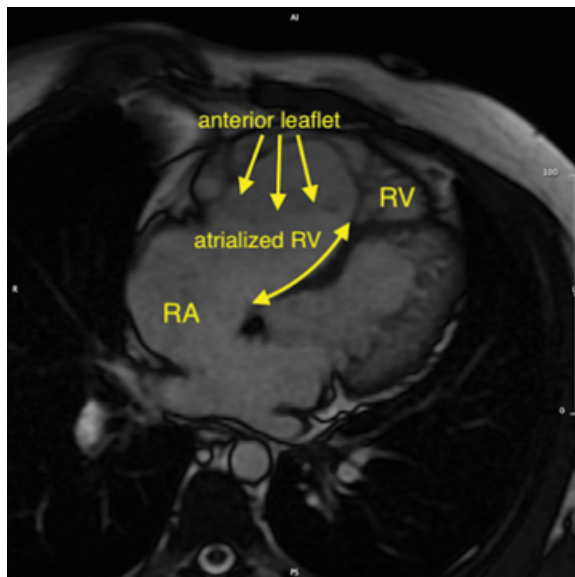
Ebstein anomaly. Four-chamber magnetic resonance imaging of severe Ebstein anomaly. There is marked apical displacement of the tricuspid septal leaflet creating a very small right ventricle and a large atrialized right ventricle. Courtesy of Michael Taylor, MD.
